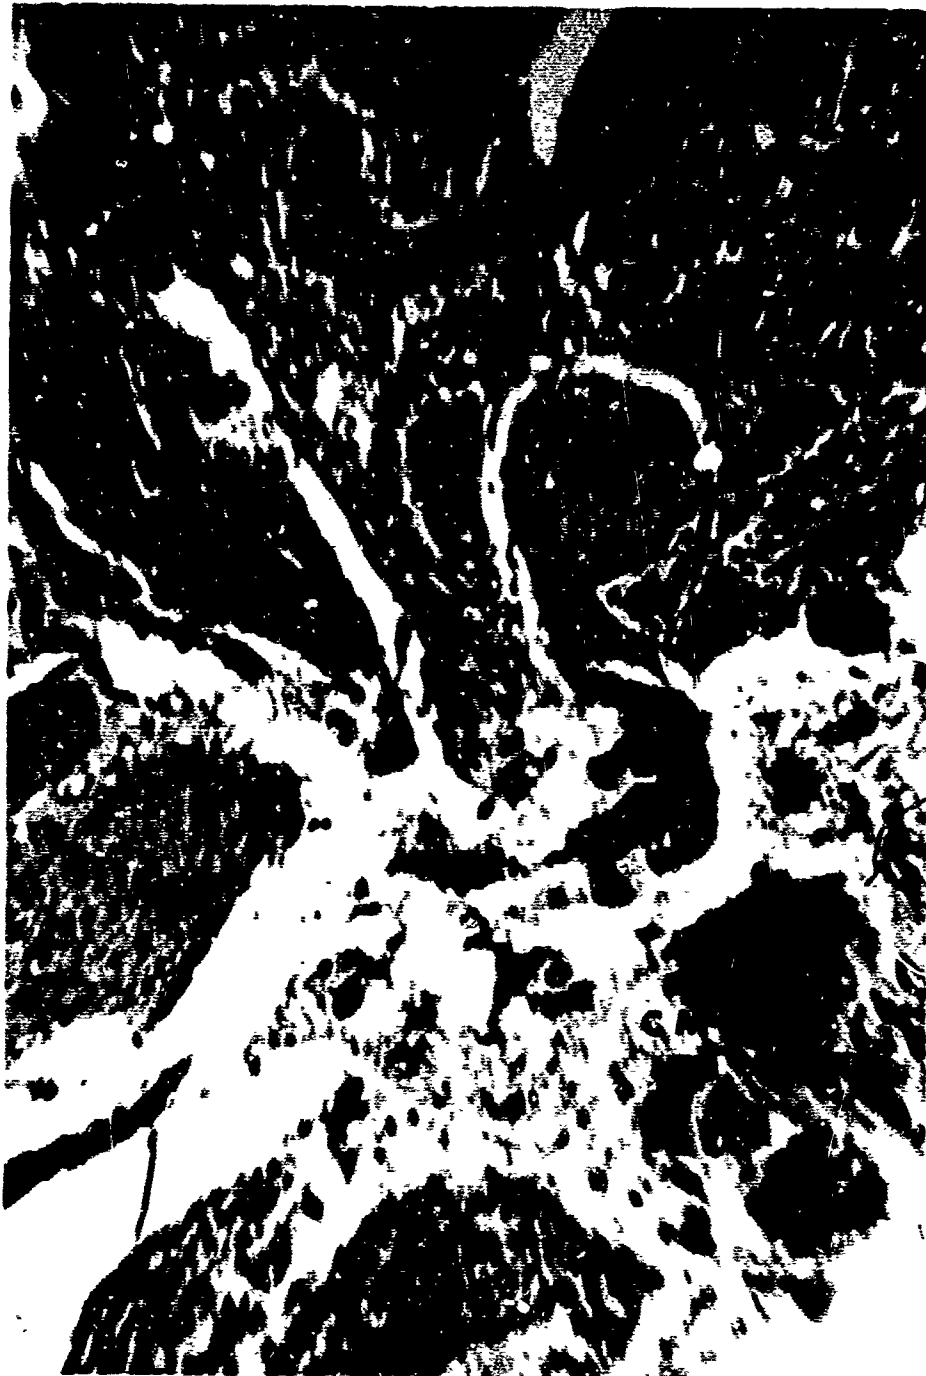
Cluster of Microorganisms contiguous to the ulceration at the crest of an interdental papilla. (CM) Cluster of Microorganisms; (CT) Connective Tissue at Base of Ulcer; (E) Part of the Remaining Epithelium. Orig. Mag. 100X
